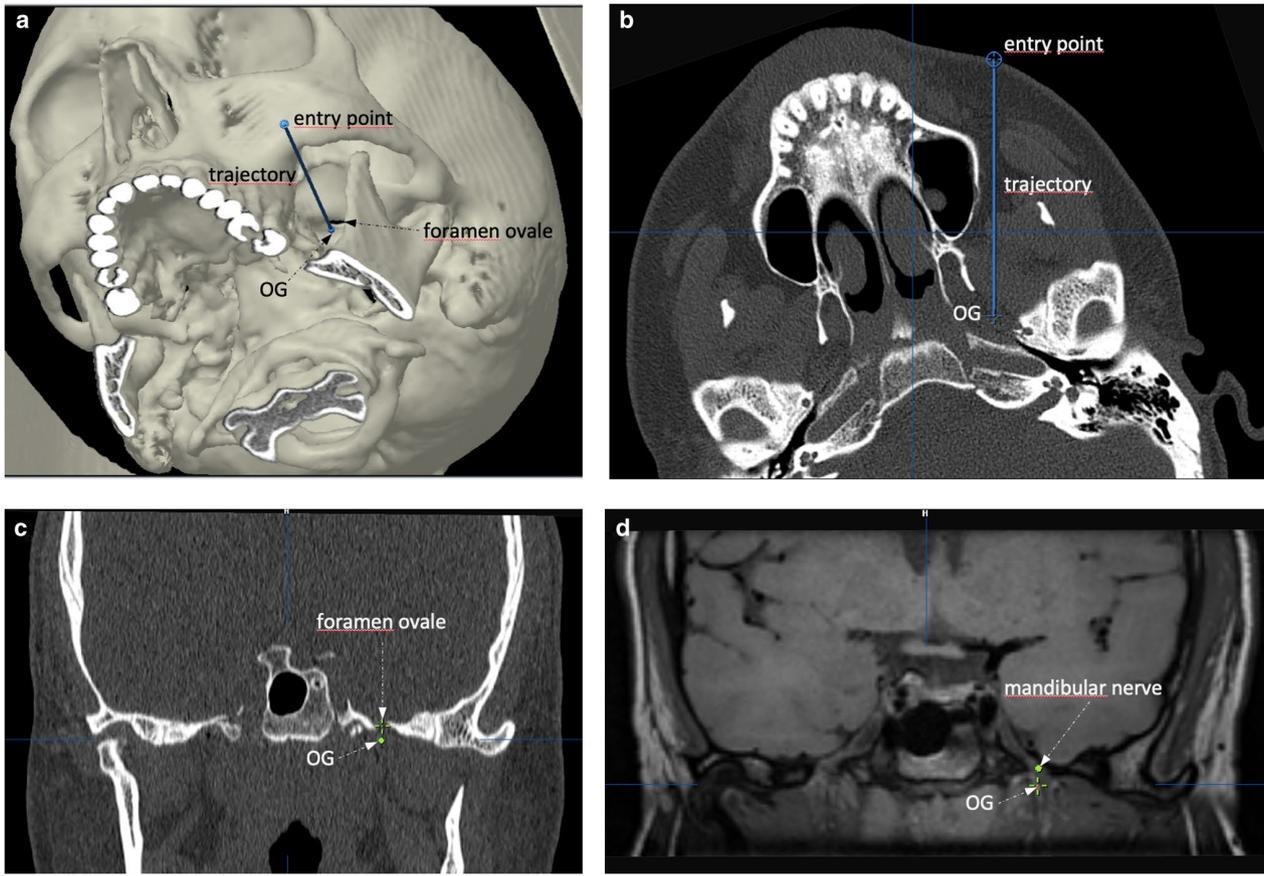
Example of the trajectory planning in patient number 6. (a) 3D reconstruction of the trajectory toward the left OG (antero-infero-lateral view). (b) modified axial plan (trajectory-plan) on a CT scan to show the trajectory from the entry point to the left OG situated in the infratemporal fossa. (c) coronal plane through the left foramen ovale (green cross) on CT-scan. The left OG (green dot) was localized 4.5 mm inferior to the inferior aspect of the foramen ovale. (d) T1 image taken with a 3-Tesla scanner; coronal plane. The green dot is situated over the left mandibular nerve exiting the foramen ovale. The left OG was localized directly medial to the mandibular nerve and 4.5 mm inferior to the foramen ovale. OG: otic ganglion.
